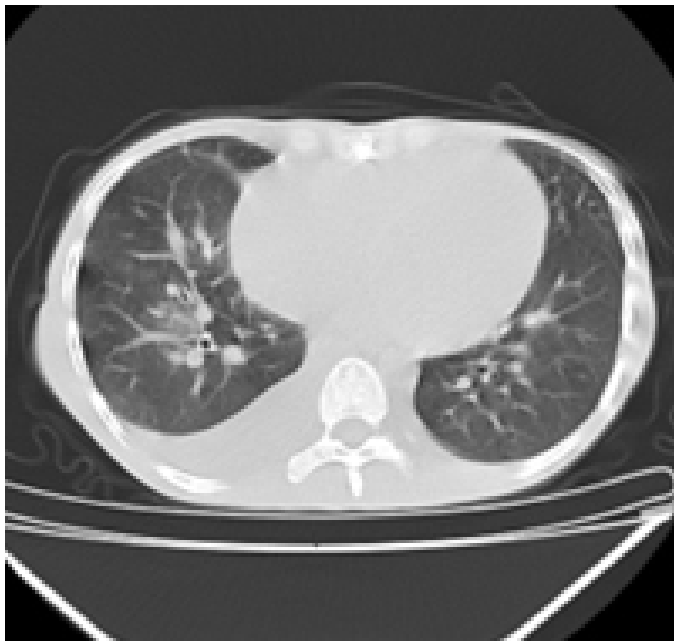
Thoracic CT scan at the time of initial presentation
